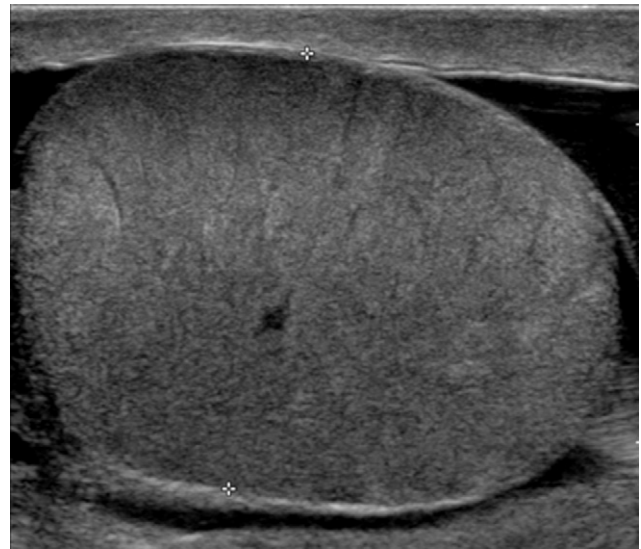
Epididymo-orchitis. B-mode sonography: hypertrophied testis with homogenous parenchyma, fine striations.
